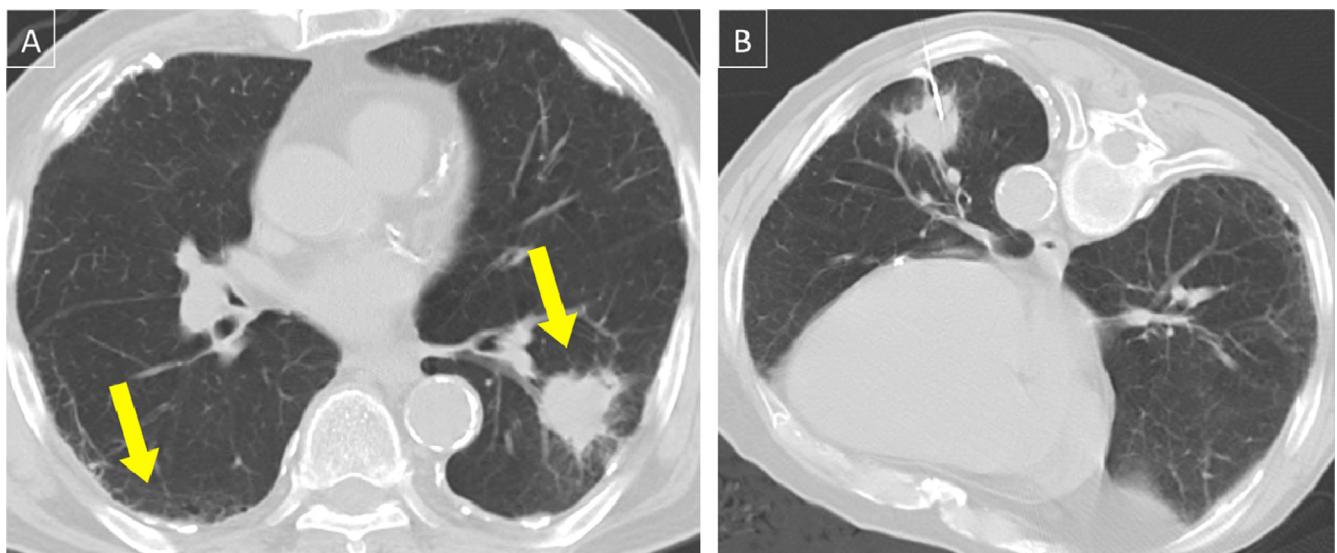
Bronchogenic carcinoma. CT image obtained at lung windows demonstrates a pulmonary mass in the left lower lobe. (A) Multiple bilateral pleural plaques and subpleural bands or fibrosis can be noted. (B) CT-guided biopsy of this mass demonstrated adenocarcinoma. (Color version of figure is available online.)
